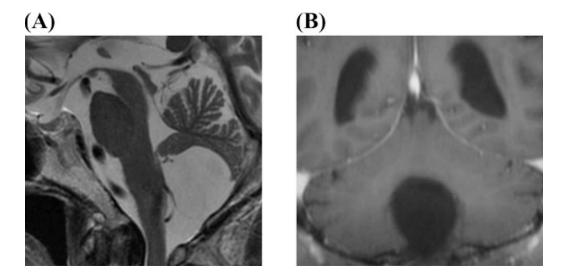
A 76-year-old female presented with unsteadiness and gait disturbance revealed an arachnoid cyst at the foramen of Magendie on MRI (A; sagittal section on T2WI and B; coronal
